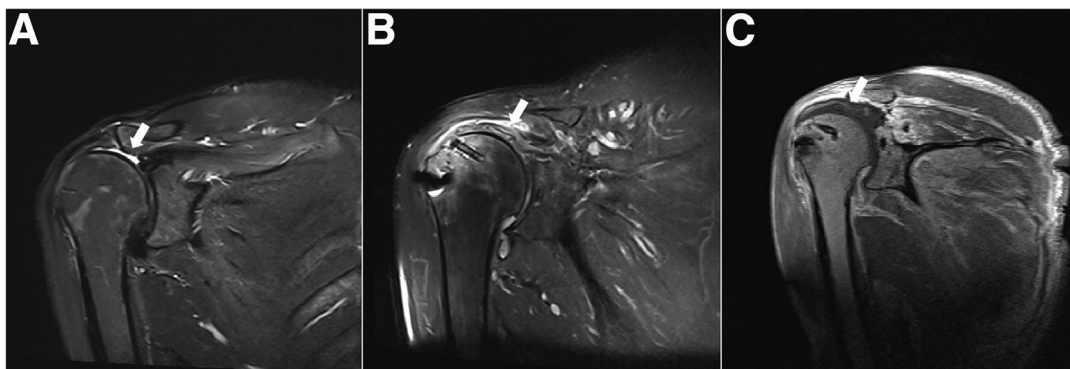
(A) Preoperative T2-weighted magnetic resonance imaging (MRI) in coronal plane showing massive rotator cuff tear retracted at glenoid level (arrow). (B) Postoperative T2-weighted MRI in coronal plane at 3 months showing bamboo raft graft (arrow). (C) Postoperative T2-weighted MRI in coronal plane at 12 months showing bamboo raft graft (arrow).
